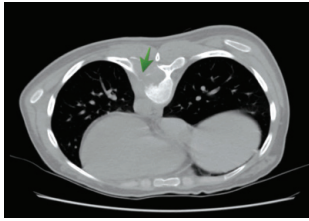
1 CT Thoracic vertebrae: Lytic lesion involving left costo-transverse articulation(Green arrow)
